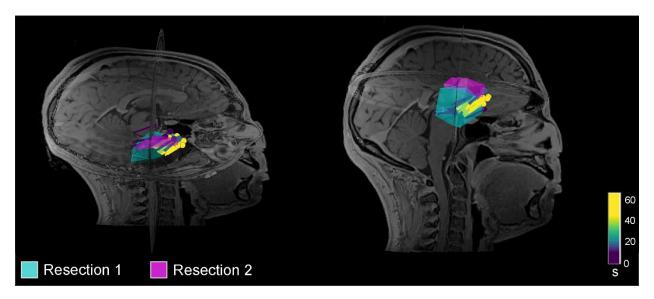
Dipole clustering and distance of dipoles from resections. The magnetic resonance imaging (MRI) of a 17-year-old female who had resections in the right temporal region (Patient 9 in Table 7) who was seizure free after second resection guided by magnetoencephalography. The ECDs are closer on average to the second resection (1.5 mm away) compared to the first resection (2.4 mm away).
